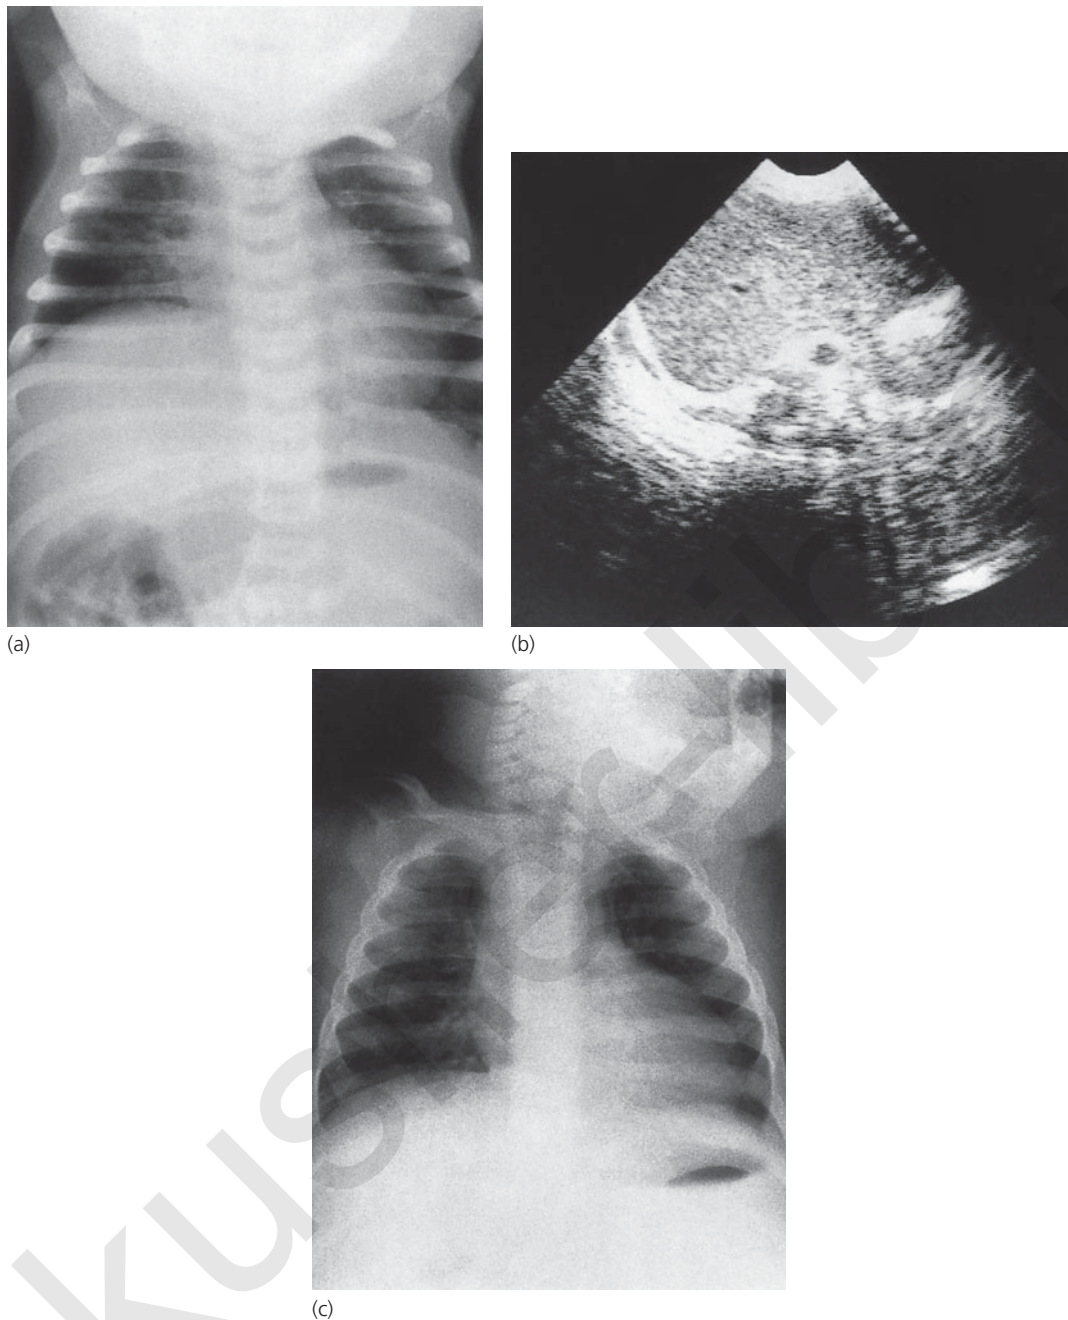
Phrenic nerve paralysis. (a) Chest x-ray shows elevated right diaphragm. (b) Transverse real-time sonogram showing blurring in the region of left diaphragm due to respiratory movement. Right diaphragm did not move and is sharply outlined along the liver. (c) Chest x-ray three months later shows normal right diaphragm after conservative treatment.
